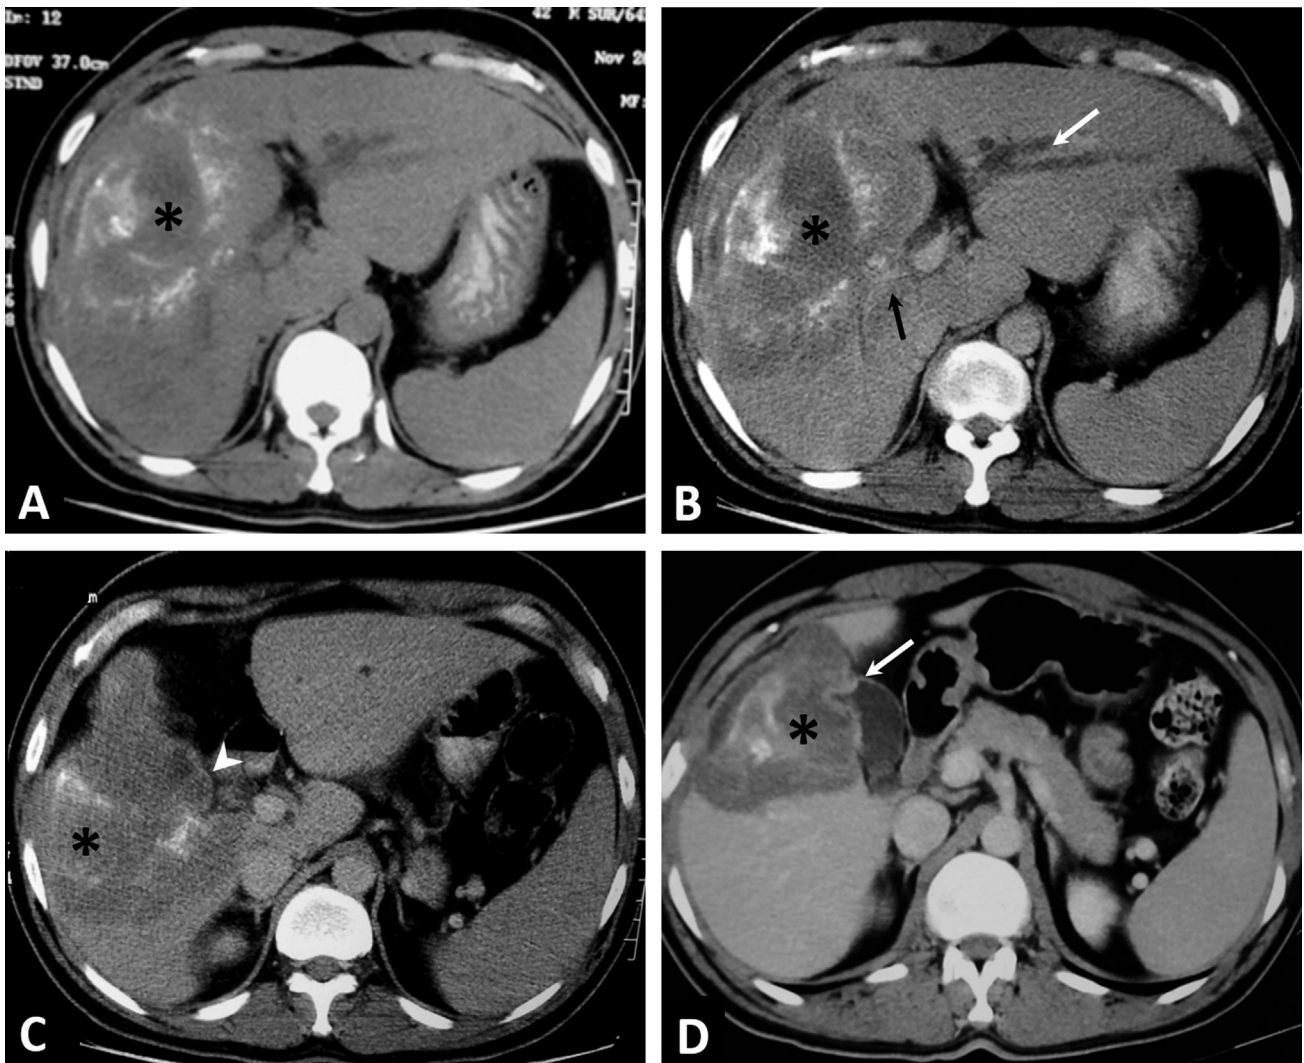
Non-contrast-enhanced (A) and contrast-enhanced CT scans (B and C) of the patient at presentation show an ill-defined hypoenhancing lesion in segments 4B, 5, and 8 of the liver, with amorphous calcification (asterisk), with invasion of the gall bladder (arrow head in C) and the right portal vein (black arrow in B) and dilatation of the intrahepatic biliary radicles of the left lobe (white arrow in B). (D) Contrast-enhanced CT scan performed 6 years earlier shows a smaller sized lesion (asterisk) with calcification and gall bladder involvement (arrow), but without biliary dilatation.
